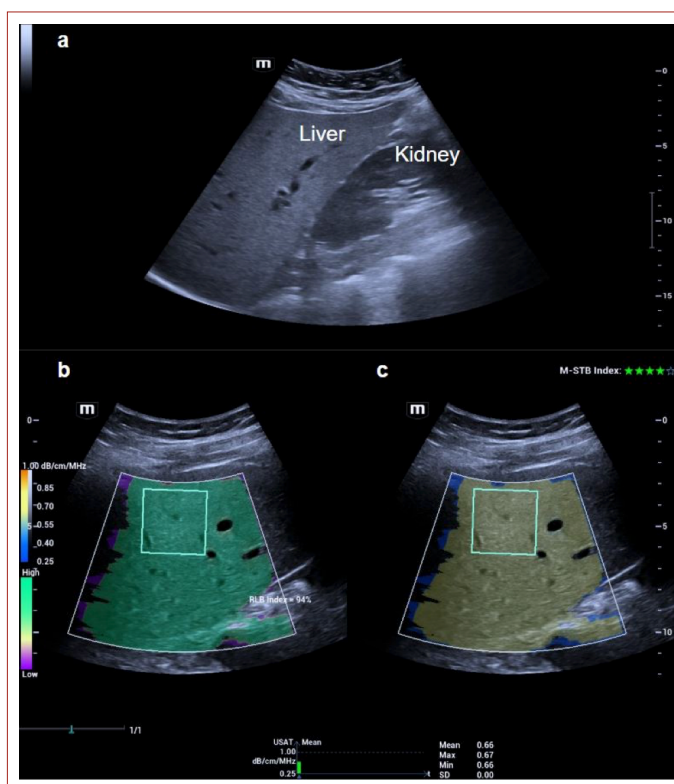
Conventional grayscale ultrasonography (a), increased hepatic echogenicity relative to the renal cortex is observed. Despite this elevation, vascular structures within the liver and the posterior diaphragm remain clearly visualized, which is characteristic of Grade I hepatic steatosis. In quantitative ultrasonography, a reliability map is displayed alongside the B-mode image to evaluate the accuracy of measurements (b). Green areas indicate regions where data was acquired optimally. An attenuation index is also displayed, with values exceeding 90% reliability being recommended for diagnostic confidence. Measurements are taken from the hepatic parenchyma using a region of interest measuring around 3 cm. In this case, the observed mean attenuation value of 0.66 dB/cm/MHz is consistent with Grade I hepatic steatosis (c).
